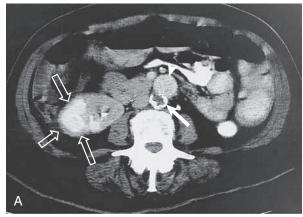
Renal infarction. (A) CT scan showing a chronic calcified infarct (open arrows) involving half of the right kidney after aortic bypass surgery. The native aorta has a densely calcified wall (arrow). The aortic graft is anterior to the native aorta (arrowhead). (B) CT scan showing acute infarct in the right kidney with decreased parenchymal enhancement (arrows).
